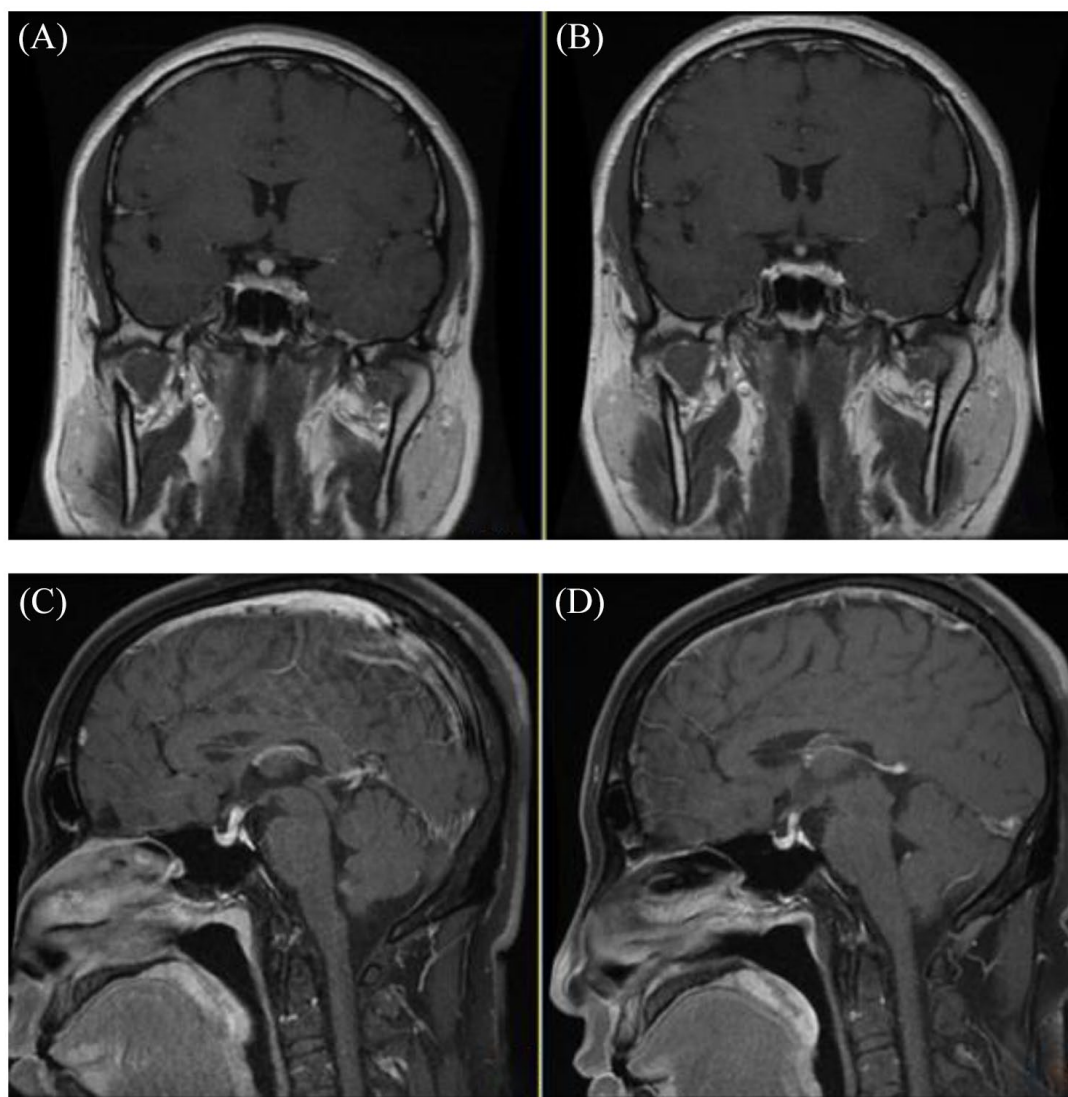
Pituitary MRI showed enlarged pituitary stalk on T1 MRI for case 1 (male, 45years old). (A) and (C) show nodular thickening of the upper part of pituitary stalk and loss of the posterior pituitary signal on T1 MRI before treatment. (B) and (D) show that the pituitary stalk became thinner 1 week after glucocorticoid and MTX treatment.
